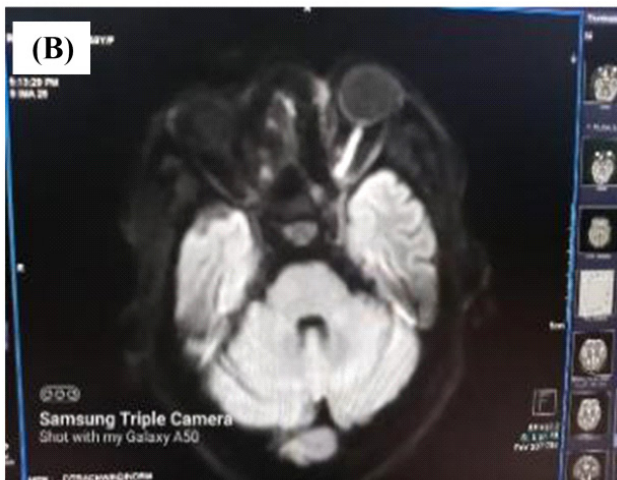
(A)Contrast MRI showed heterogenously non enhancing inferior turbinate left and Diffusion weighted MRI (B) showed low signal noted suggesting restriction of diffusion.
